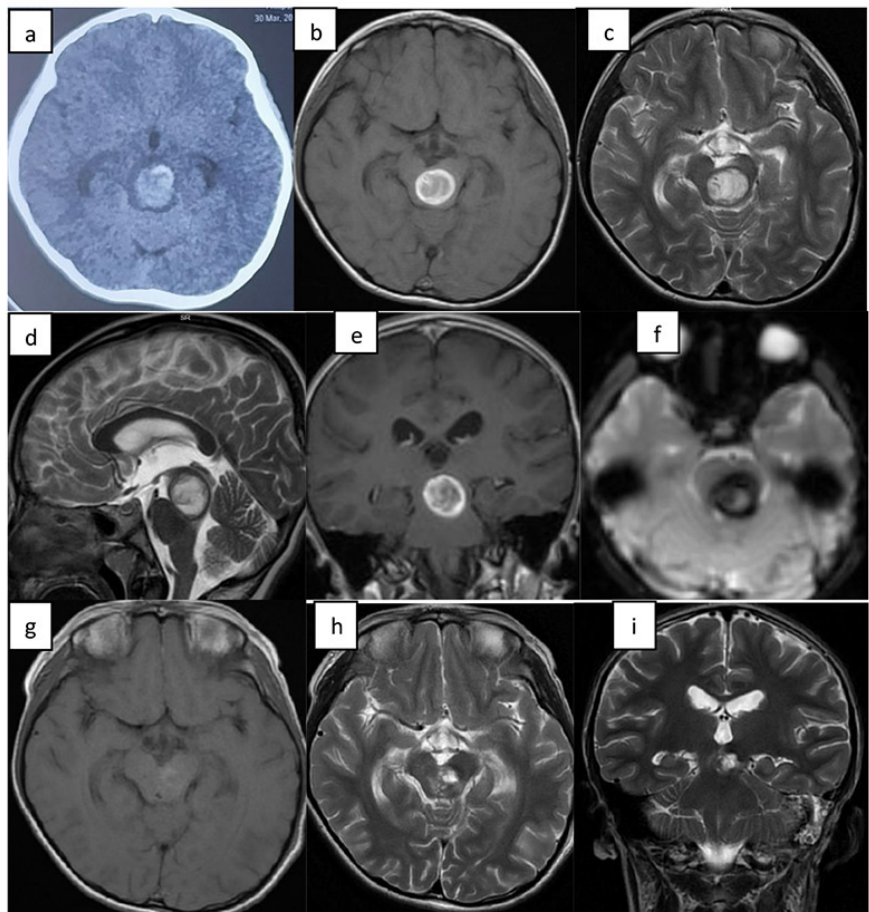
(a) Plain Head CT revealed hyperdensity mass on the brainstem. (b&e) Magnetic resonance imaging T1-weighted images show hyperintensity round mass on the mesencephalon and upper pons, and the clot expanded to the left cerebral peduncle. (c-d) T2-weighted image shows subacute bleeding of cavernoma on the ponto-mesencephalic zone. (f) Diffusion-weighted image (DWI) shows attenuation in the middle of the mass. (g) Post-operative T1-weighted images show small residual mass. (h&i) Post-operative T2-weighted images show hyperintensity on the mass was reduce with mix intensity in the median of pons.
